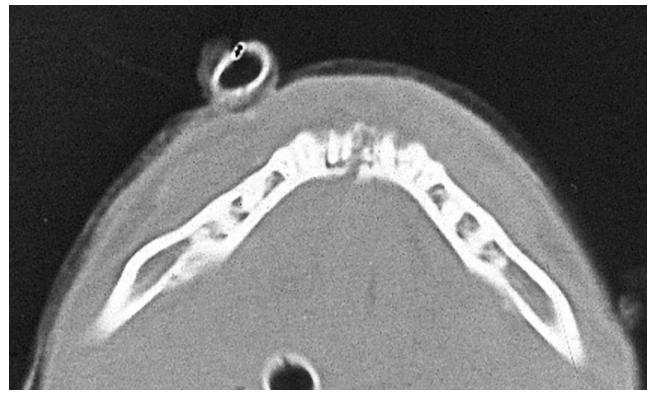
CT of a midline fracture.
